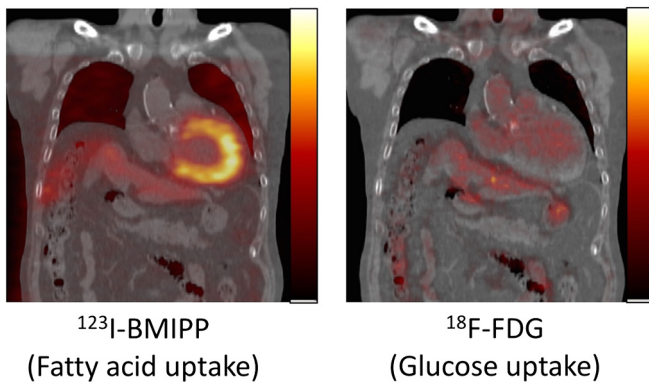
In vivo* chest coronal images of radionuclide metabolic imaging in a healthy subject under fasting conditions. Increased cardiac ^{123}I -BMIPP uptake (fatty acids uptake marker) (arrow) as compared to ^{18}F -FDG uptake (glucose uptake marker) is identified.
